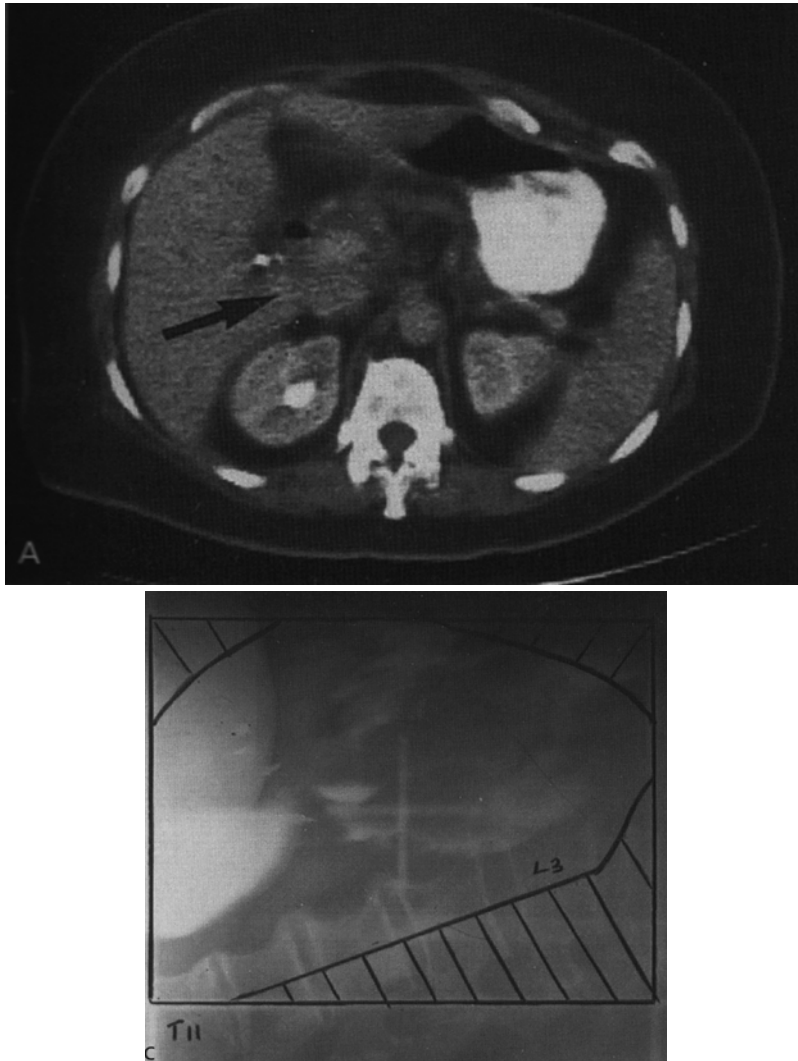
External beam four-field technique for a pancreatic head lesion. (a) The lesion on CT scan. Note the dilated pancreatic duct and relation of the pancreas to the duodenal loop and stomach. (b) The anteroposterior/posteroanterior (AP/PA) field, which includes the tumor with the approximately 3-cm margin of the pancreas (body), the duodenal loop (plus approximately 50 % of the right kidney), and the nodal area at risk. Most of the left kidney
